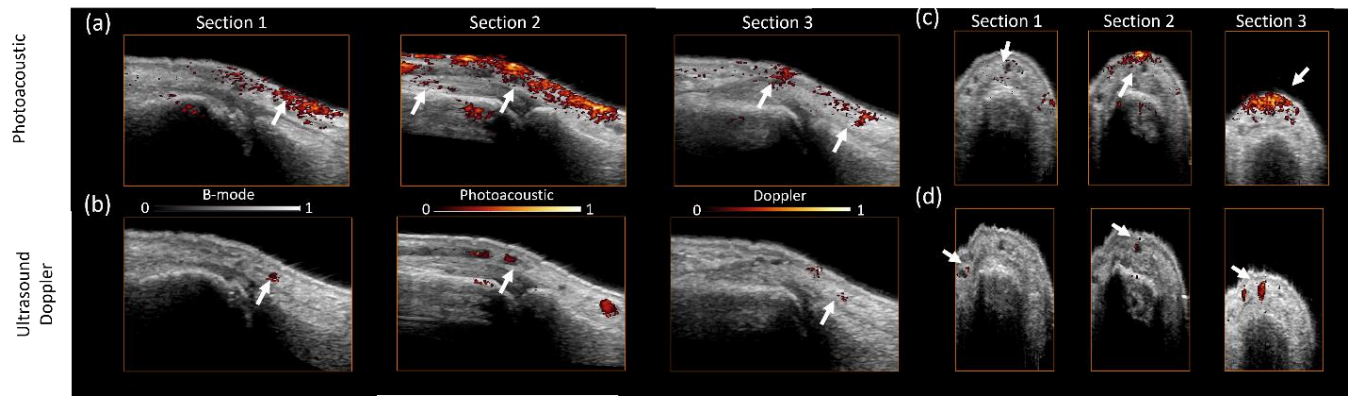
Series of a RA patient's right PIP2 joint images. (a) Long-axis US B-mode images (gray scale) with superimposed PA signals (color scale). (b) Long-axis US B-mode images (gray scale) with superimposed power Doppler US signals (color scale). (c) Short-axis US B-mode images (gray scale) with superimposed PA signals (color scale). (d) Short-axis US B-mode images (gray scale) with superimposed power Doppler US signals (color scale). White arrows mark the hyperemia area in PA and the large vessels in Doppler.
